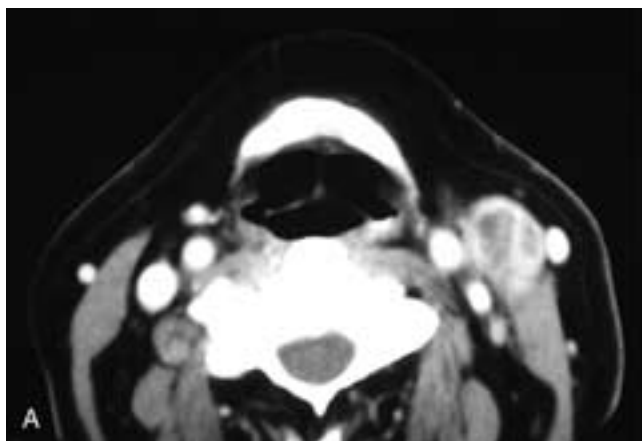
Axial contrast-enhanced CT scans on two different patients, both of whom had a slightly tender, pulsatile mass in the left neck. In A, there is a necrotic metastatic node adjacent to the carotid artery. The arterial pulsations were transmitted by the node to the skin surface. In B, there is a nonenhancing zone around the left carotid artery, and the lumen of the artery is slightly reduced compared to the right carotid artery. This patient had an arteritis.
